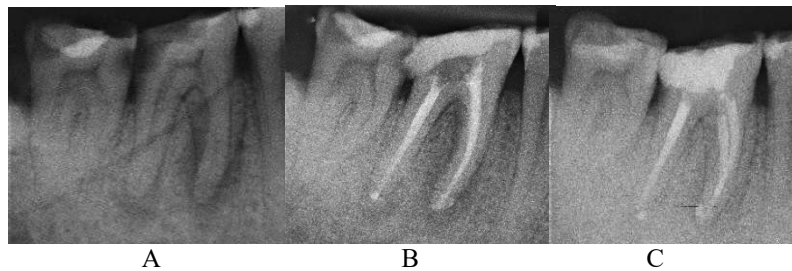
Case 1 (tooth 46): A. Initial radiographic finding; B. Root canal filling; C. The case in 1 year follow-up.
